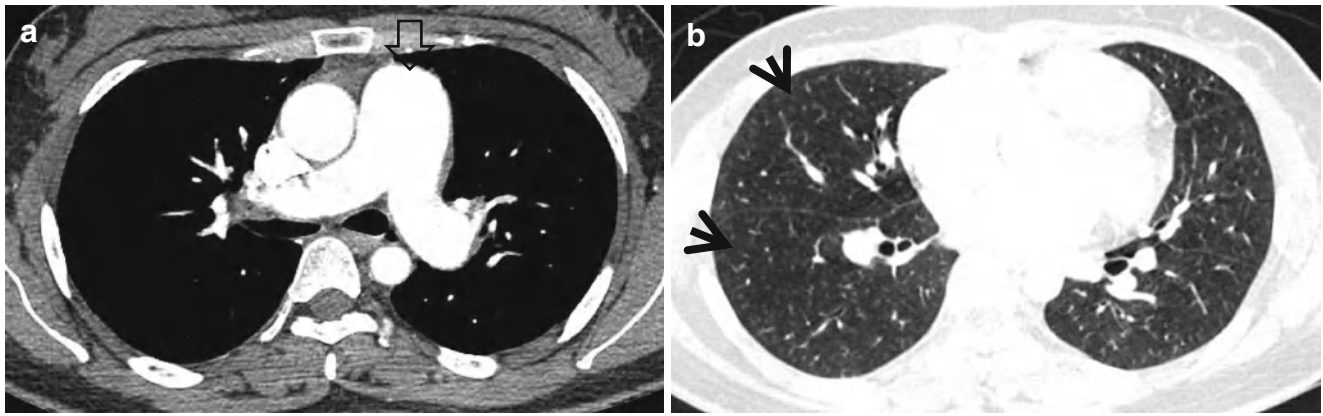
Mosaic perfusion in a 28-year-old woman with idiopathic pulmonary arterial hypertension. (a) Mediastinal window image of enhanced CT (1.0-mm section thickness) scan obtained at level of main
